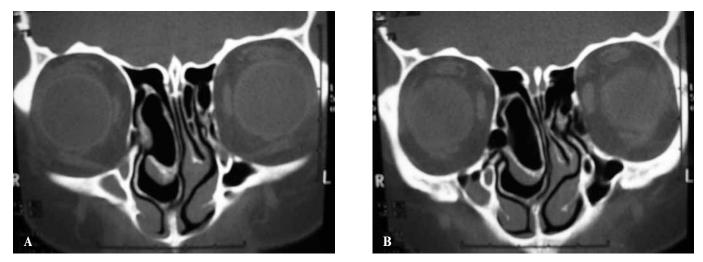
CT scan demonstrating the pneumatization, the drainage ostia and the attachments of the middle turbinates. A. Ostium of the inner concha bullosa, B. Ostium of the outher concha bullosa.
